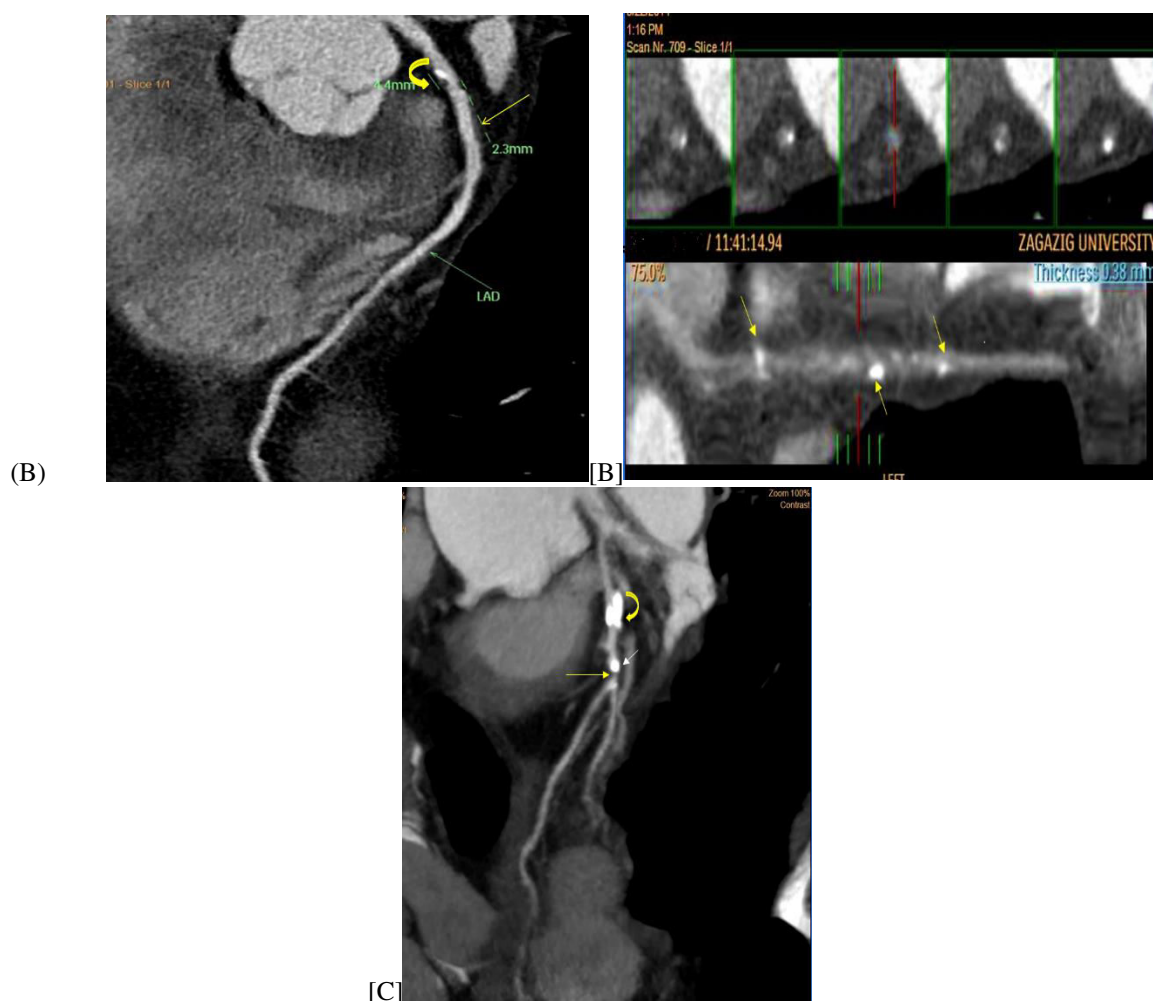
CT images of non-calcified plaque, mixed plaque and calcified plaques [a]Example of mixed and non-calcified plaques MDCT curved multiplanar reconstruction of the left anterior descending artery [LAD] showed a mixed calcified plaque in the proximal segment [Curved arrow] and non-calcified plaque in the mid-segment associated with non-significant obstruction of the lumen [$<50\%$][Straight arrow]. [b] Example of multiple spotty calcified plaques of left anterior descending [LAD][arrows] without significant luminal obstruction. [c]MDCT curved multiplanar reconstruction of the left anterior descending artery [LAD] showed calcified [curved arrow] and mixed [Straight arrow] plaques in the mid-segment of the LAD.Note the artifact of "blooming" due to partial volume averaging of dense calcium [which typically has an elevated atomic number]. The median of MDCT densities of the plaques at this level was 780 HU.
